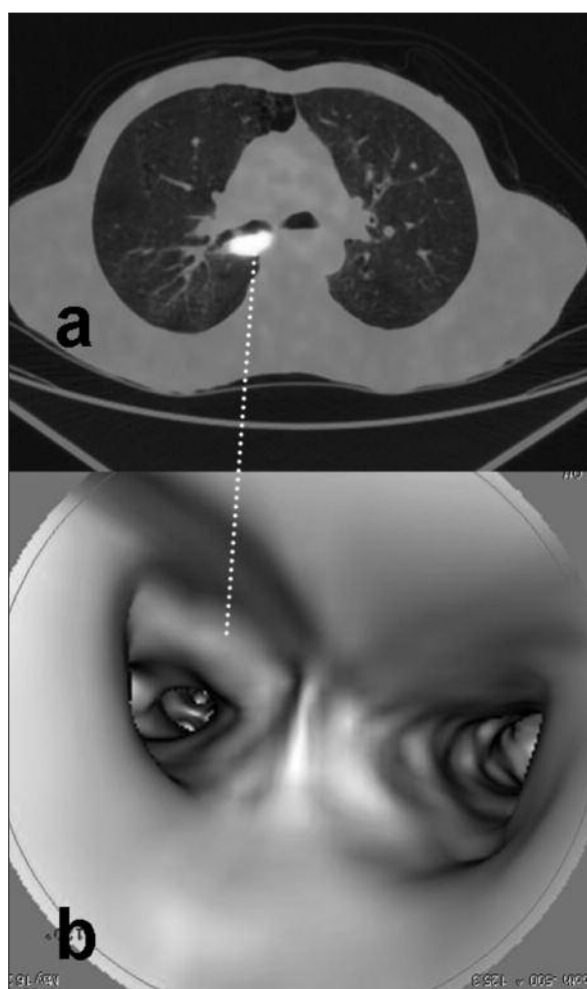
In fused images, *(a)* although the lumen is not significantly constricted due to submucosal infiltration, *(b)* the pathology can easily be detected with VB performed under the guidance of FDG uptake (*white line*). The depth of the lesion from the surface, extensions, and configuration can also be investigated, if needed.
